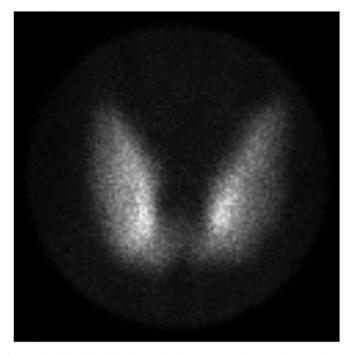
Thyroid scintigraphy using technetium-99m pertechnetate, demonstrating a normal thyroid configuration with uniform radionuclide uptake. The Radioactive lodine Uptake done prior to the scintigraphy was 35% 24 h after ingesting 11 uCi of iodine-131 (reference range 10% to 35% at 24 h).
